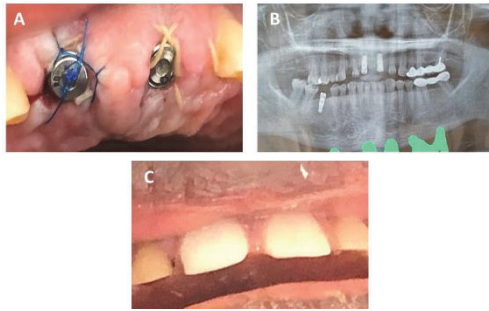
Postoperative images: A. Intraoral clinical image showing the implants replacing both maxillary central incisors at 3 days post-placement before provisional restorations loading; B. Postoperative Orthopantomograph before provisional restorations loading; C. Intraoral clinical image showing the loading of provisional restorations
